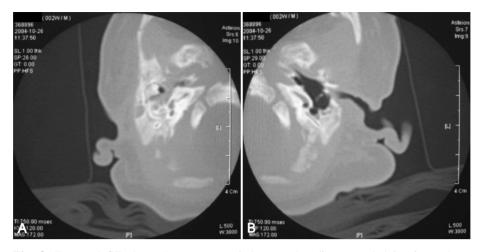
Temporal CT shows Rt. ear congenital external auditory canal deformity and os sicle deformity (A) and normal Lt. ear (B).
